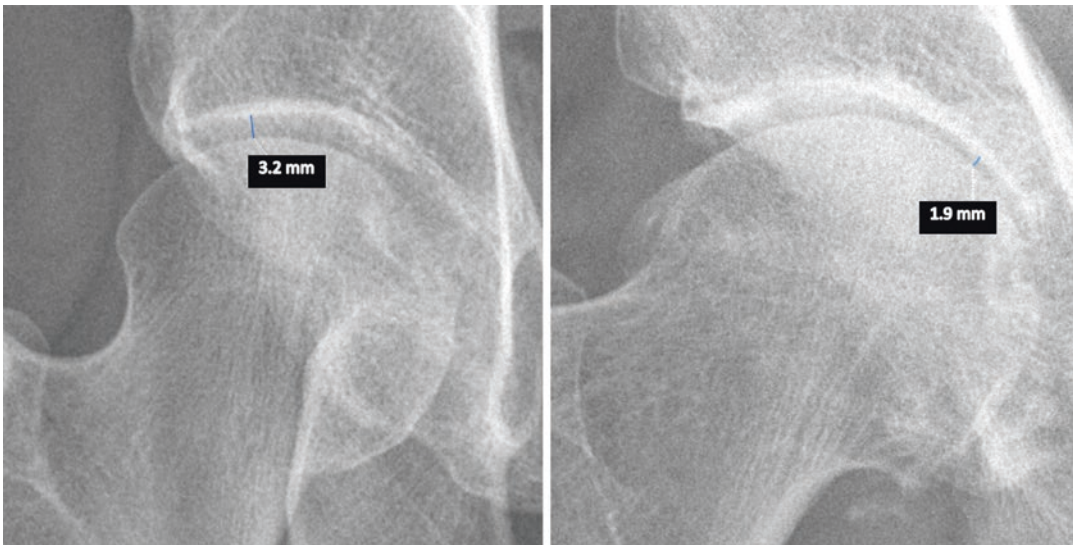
Examples of measurement of minimum joint space width. This measurement should be carried out in an AP pelvic or hip-centred radiographs. Joint space
